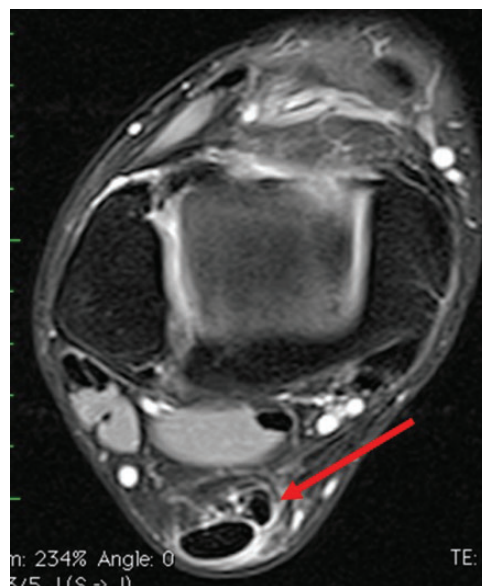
Magnetic resonance imaging scan noting a thickened plantaris tendon (arrow) consistent with tendinosis and surrounding inflammatory changes adjacent to Achilles tendon.
